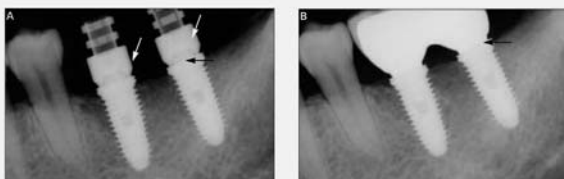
Periapical radiograph was taken at the time of (A) immediate loading and (B) 3-months after continued loading. The platform (black arrows) was a reference point to measure marginal bone loss. Provisional resin restoration was made by polymethylmethacrylate that is radiopaque. Therefore, only temporary cylinders are seen (white arrows).
